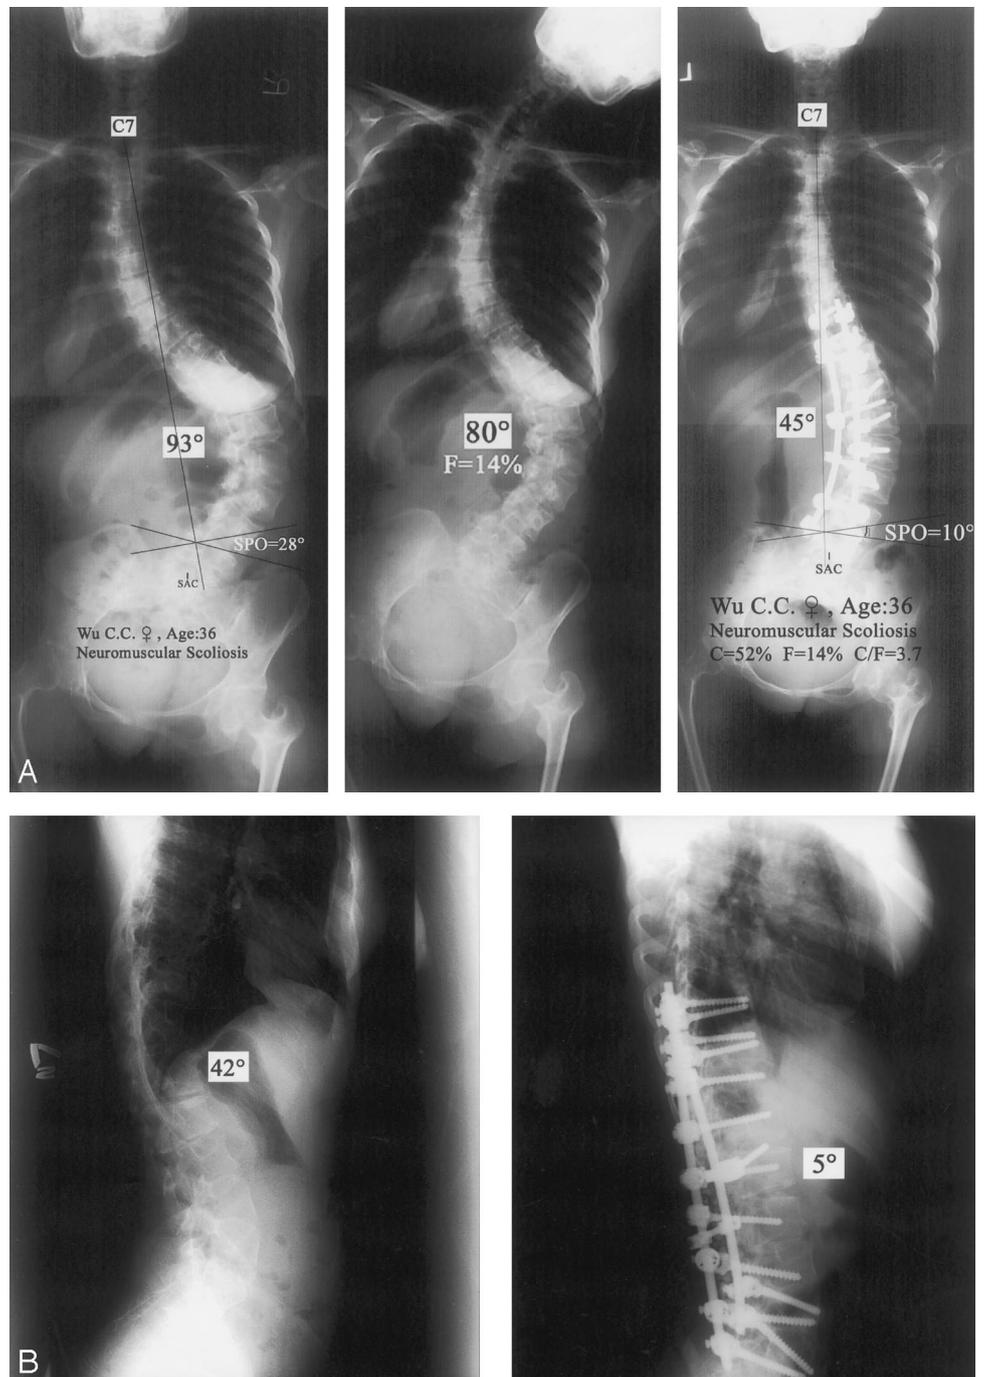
A 36-year-old woman with a 93° neuromuscular scoliosis. Radiographic views show (A) preoperative AP side bending and postoperative AP. B, Preoperative and postoperative lateral.
